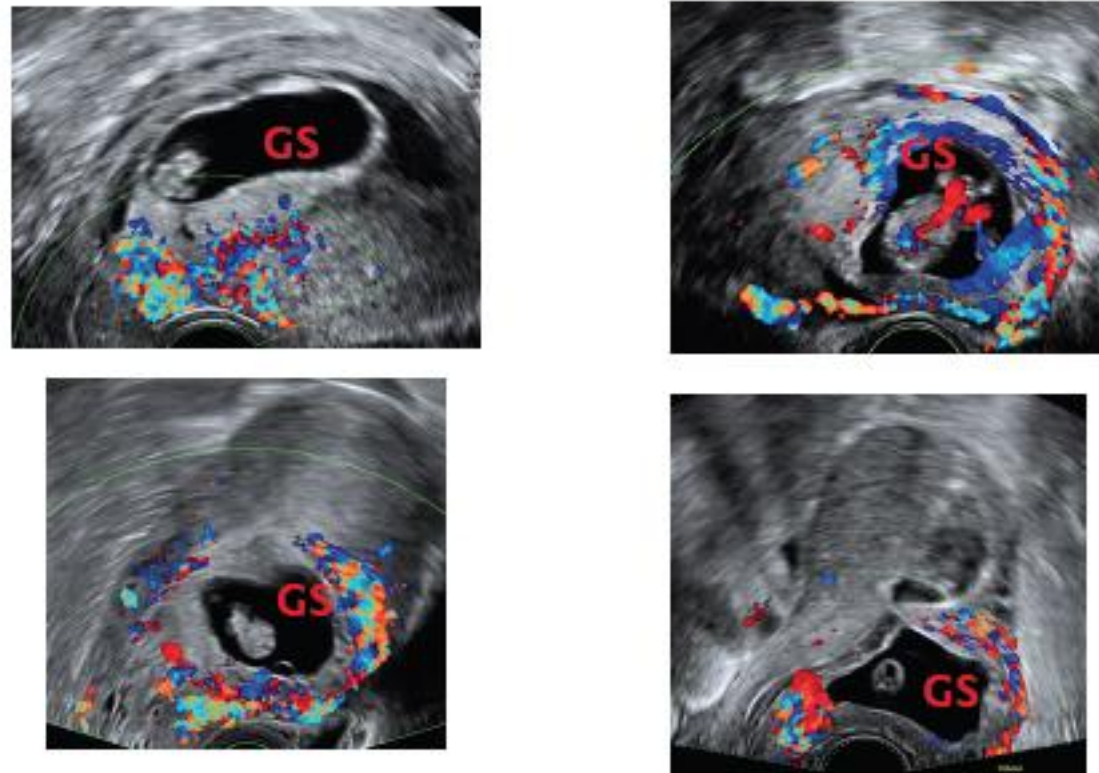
Using Doppler to avoid false positive diagnosis
